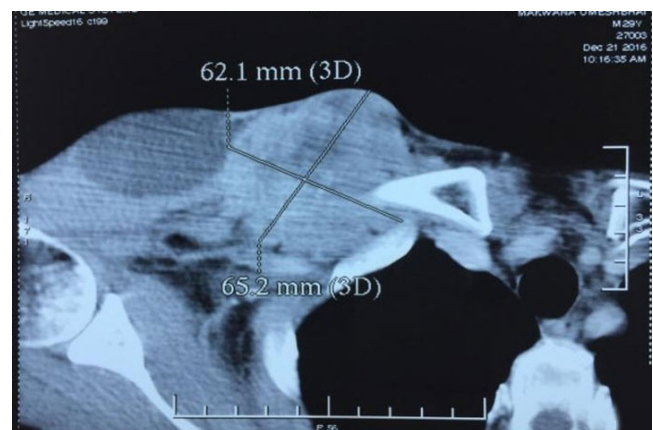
Computed tomography of thorax showing the chest wall lesion
